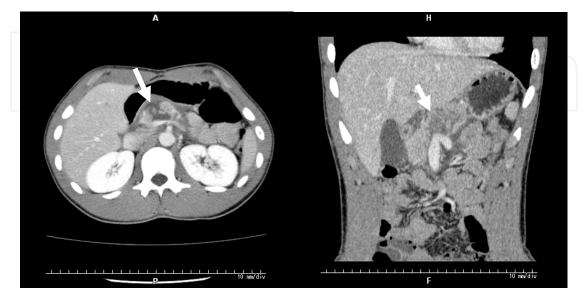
Enhanced CT revealed an obvious laceration of the pancreas neck. (white arrow)
